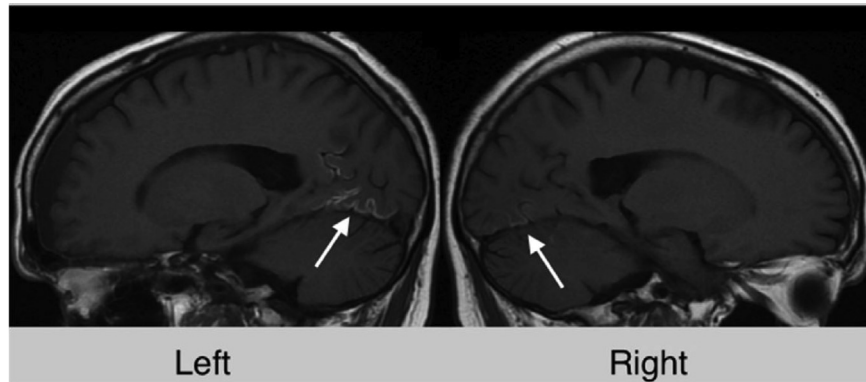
Structural MRI scan for the topographical disorientation case, L.H. High signal in the occipital gyri areas as shown by his MRI scan. Cortical laminar necrosis was reported in the bilateral posterior and medial occipital lobes and left inferomedial parietal lobe (Rivest et al., 2018; note: coronal views were not available based on the resolution of this clinical scan).
